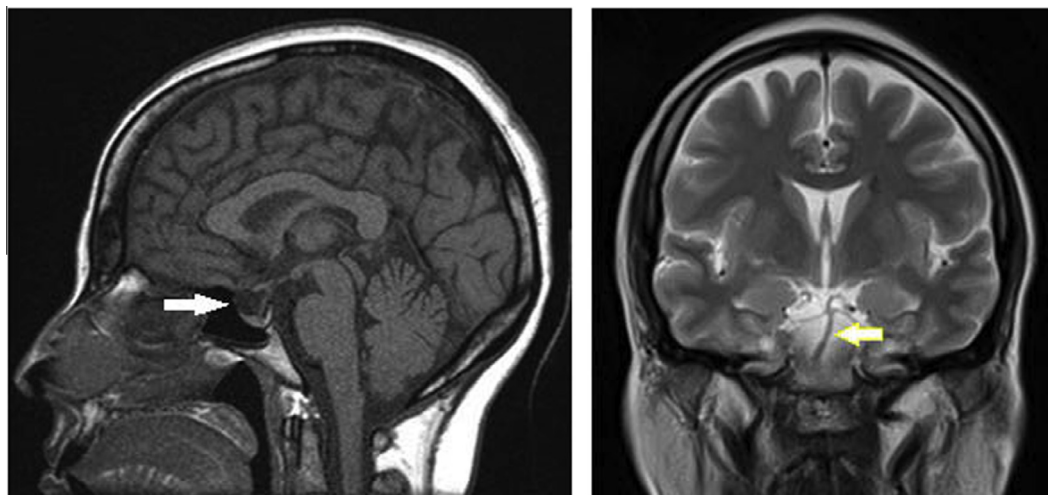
Magnetic resonance imaging of patient's brain: enlargement of pituitary fossa which is filled with CSF along with thinned, compressed pituitary gland (white arrow) in non-contrast T1 weighted sagittal image (left panel); also the pituitary infundibulum (yellow arrow) traverses the enlarged sella to meet the thinned, compressed pituitary gland at the bottom, i.e., the 'infundibular sign' in T2 weighted coronal image (right panel).
